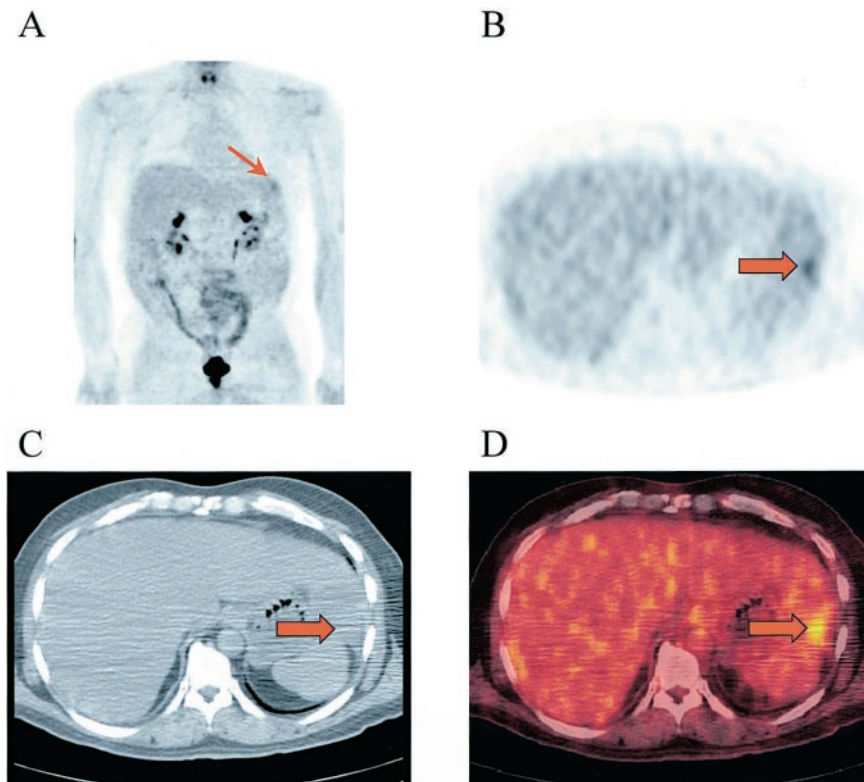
^{18}F -FDG PET images in anterior projection display (A) of patient evaluated for suspected recurrence did not clearly show abnormal foci of uptake in abdomen. Focus of moderate activity in left upper quadrant of abdomen was interpreted as splenic activity (arrow). Diagnostic impression was definitively benign. Transverse PET image (B) and fused image (D) at level of liver clearly showed small focus of mild activity at edge of a lesion on CT image (C). This lesion was interpreted as clearly malignant, and patient was classified as having metastatic liver disease. Metastasis from mucinous colorectal carcinoma was confirmed at surgery. With PET/CT, disease was correctly staged, unlike false-negative interpretation with PET alone.
